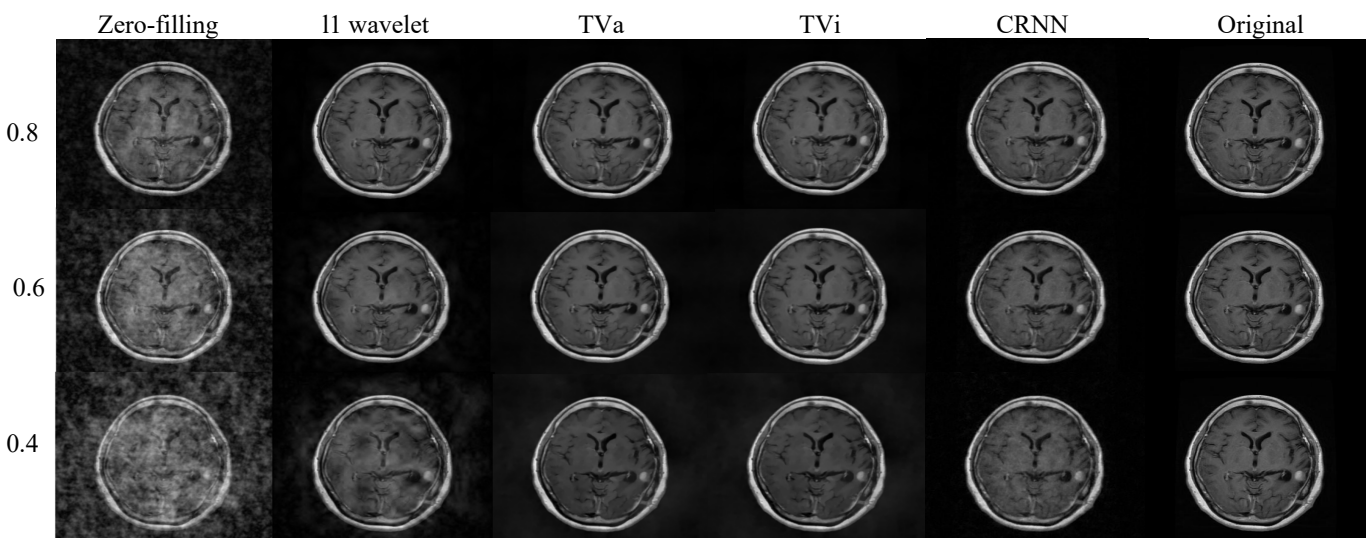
Reconstructed brain MR images based on different methods.
